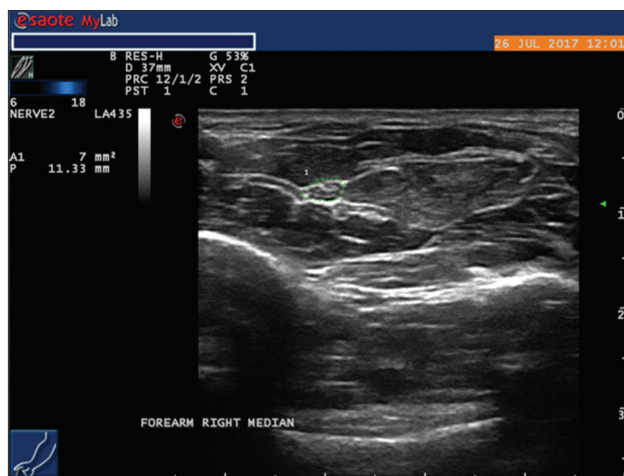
Ultrasound measurement of median nerve at one-third distal forearm (Green dash line circled)
